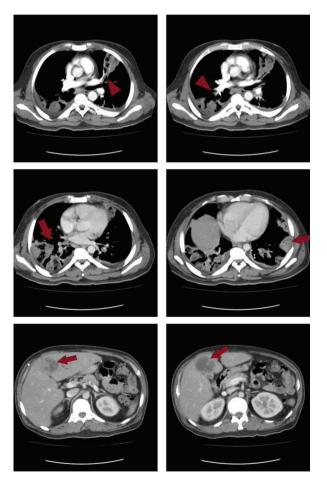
Chest computed tomography shows bilateral septic emboli (red arrowhead) with abscess formation (red arrow) and a left liver abscess (red arrow).
